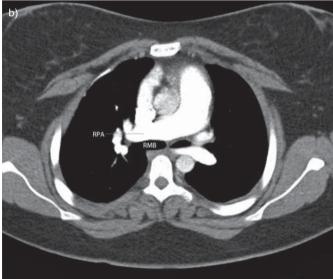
Computed tomography angiography images, at the level of a) the distal trachea (T) and b) the right main bronchus (RMB). The anomalous left pulmonary artery (LPA) originates from the posterior wall of the right pulmonary artery (RPA), passes over the right main bronchus and runs posterior to the trachea, encircling it, and goes leftwards between the trachea and oesophagus to reach the left pulmonary hilum. The left pulmonary artery is narrowed at the origin and midpoint from the impression of the right and left bronchi.
